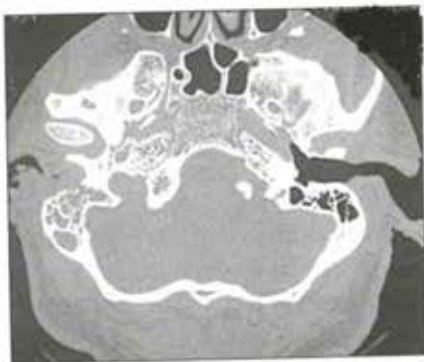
The CT scan shows bony destruction of the right temporal bone and posterior wall of the external auditory canal is missing. Mastoid air cells are secondarily involved and are pacified compared with the well-aerated left side.
